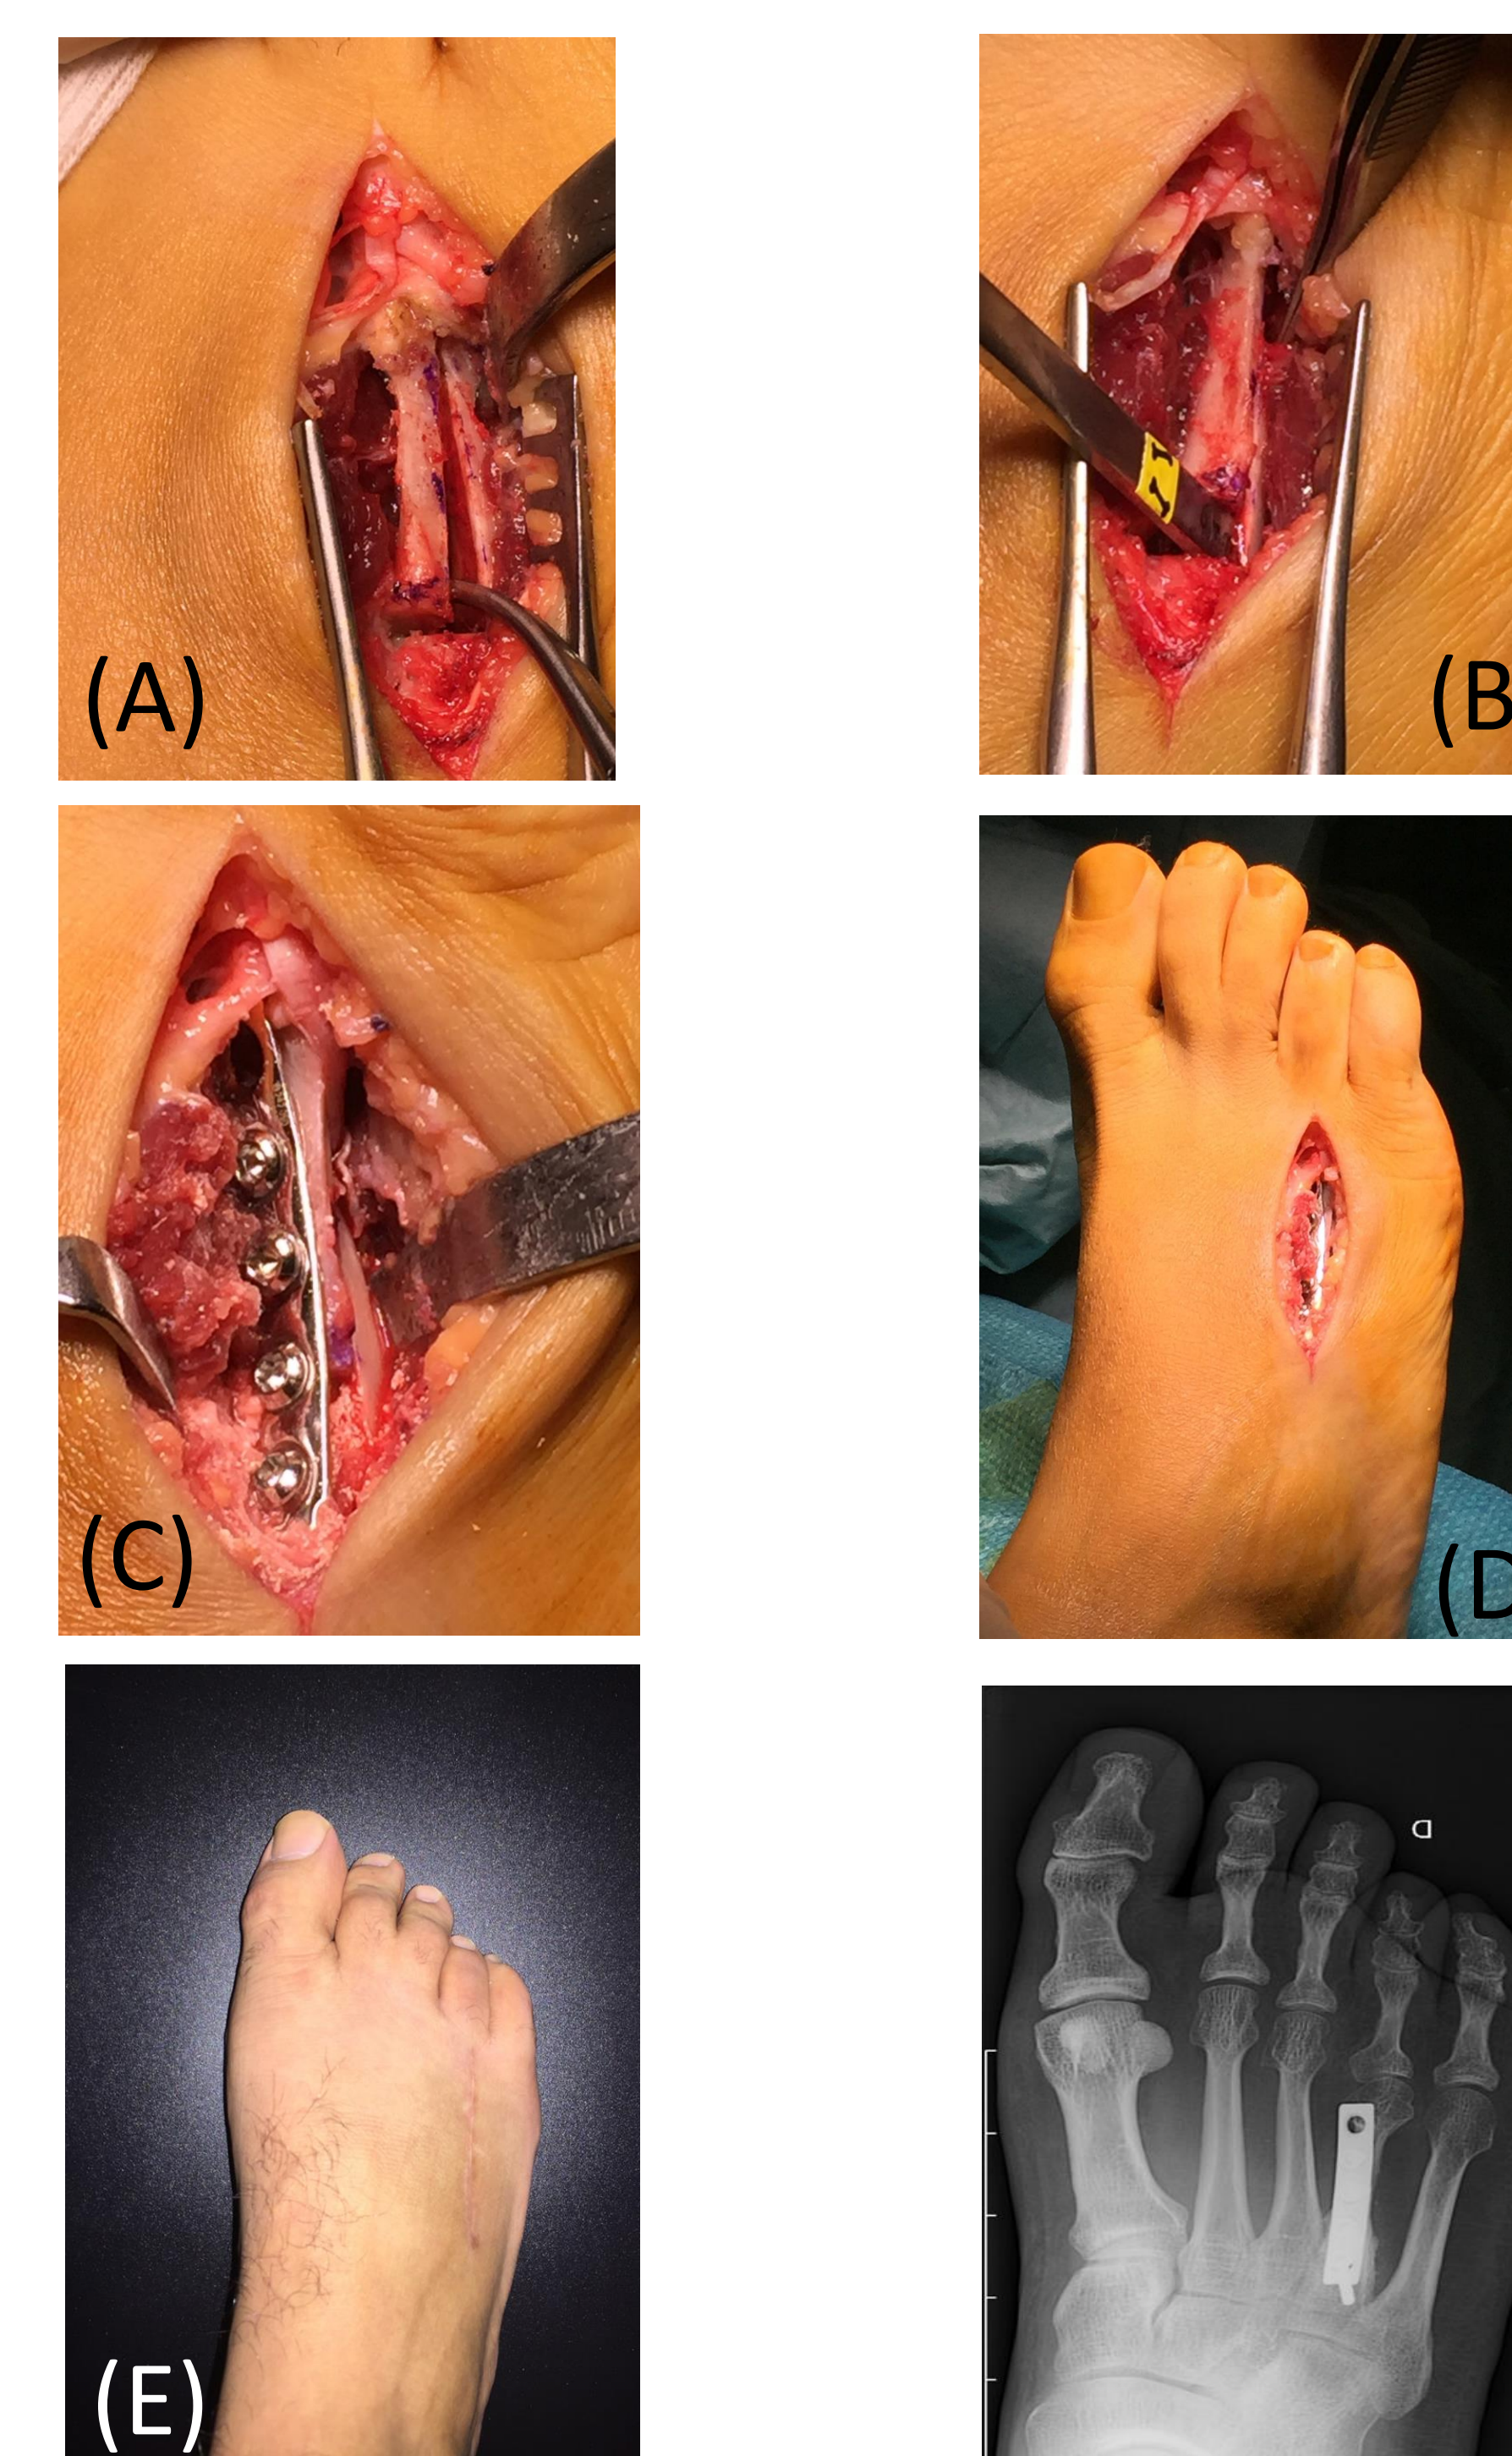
(A) Intra-operative Z-cut osteotomy (B) 12mm distraction (C) Osteotomy fixation (D) Intra-operative results before skin closure (E) 8 month post-operative (F) 8 month post-operative radiograph
